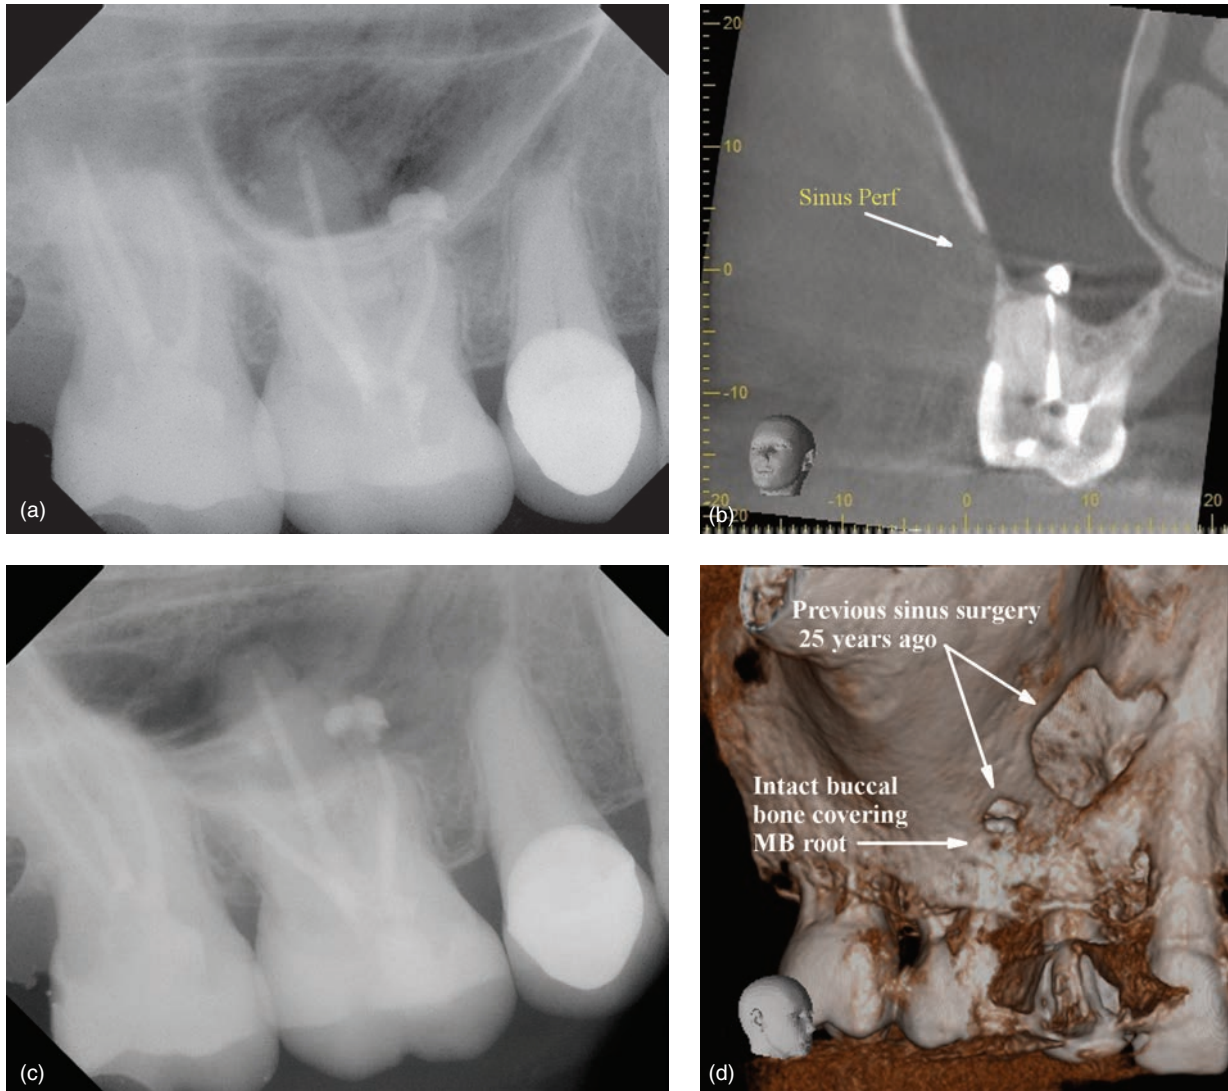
Cases representing sinus exposure, mandibular nerve, and mental foramen. (a) Previously treated maxillary first molar. Patient was symptomatic. Patient's medical history revealed previous sinus surgery. Preoperative radiograph showing previous root canal treatment and extruded filling material from the mesial canal. (b) Coronal view showing missed MB-1 canal, extruded material in maxillary sinus, and sinus perforation at the previously surgicized site; (c) Postoperative radiograph. Due to missed MB canal, non-surgical retreatment was opted for. (d) CBCT 3D rendering, showing buccal cortical perforations and the site of previous sinus surgery.
